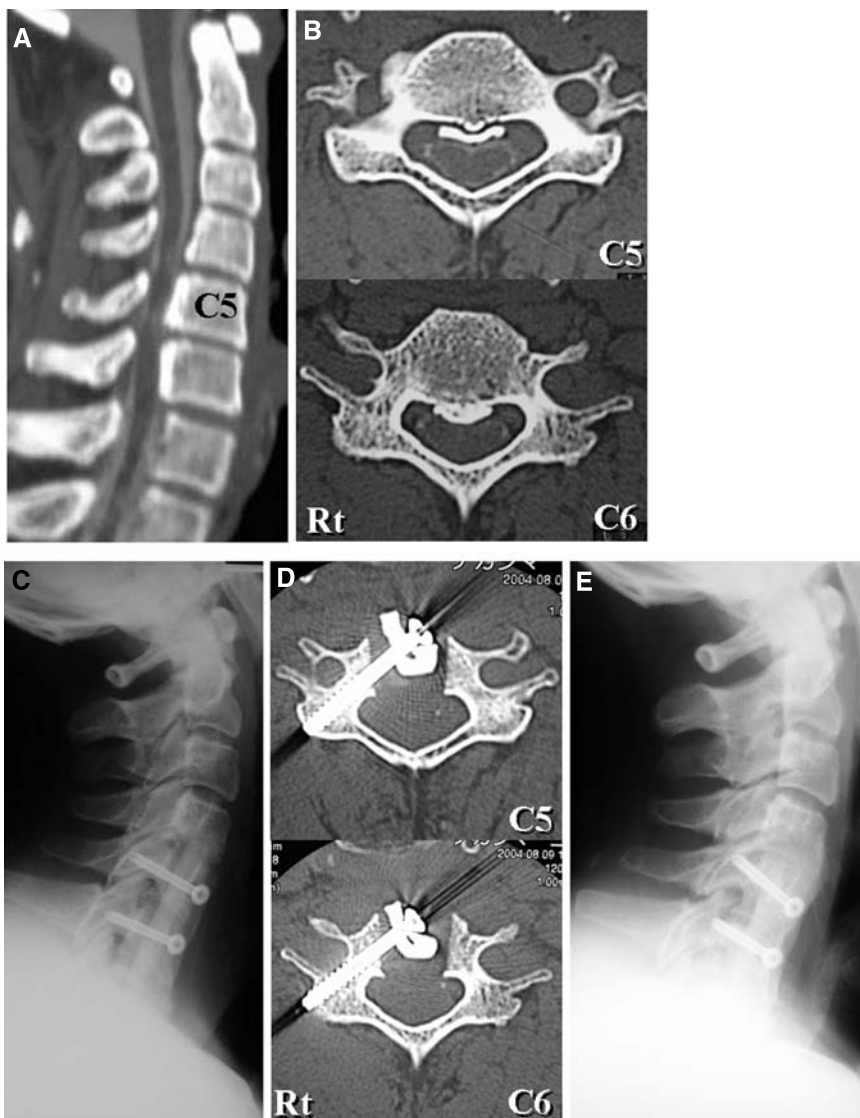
Pre-operative midsagittal reconstruction image (A) and axial images at the C5 and C6 pedicles (B) of a CT myelogram of a 44-year-old man (Patient 1) showing OPLL at C4–C6 with compression of the spinal cord anteriorly at C5–C6. Post-operative lateral radiographic image (C) and axial views of CT (D) two weeks after surgery, indicating that the screws were inserted accurately through the grafted fibula autograft and the C5 and C6 pedicles. A lateral radiographic image two years after surgery (E), showing complete spinal fusion at C4–C7
